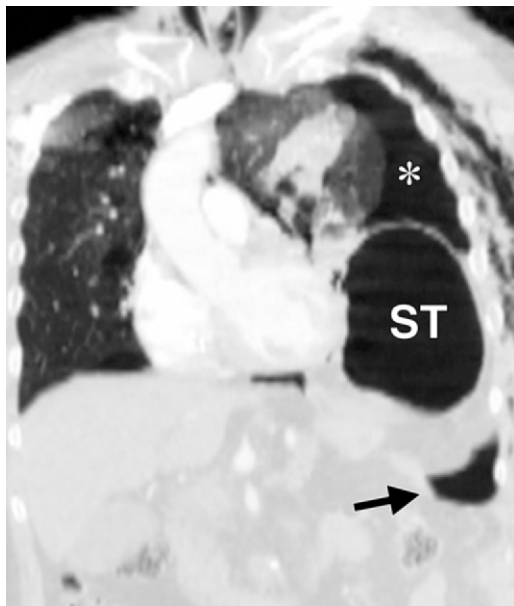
Left-sided BDR in a 60-year-old man after a motor vehicle accident. Coronal contrast-enhanced CT image shows the presence of air in the pleural space (*) and peritoneal cavity (arrow) (pneumothorax and pneumoperitoneum sign). Thoracic parietal emphysema is also seen. The stomach (ST) has herniated into the thorax and contacts the collapsed lung and pericardial sac (abdominal viscera abutting thoracic fluid or a thoracic organ sign).
